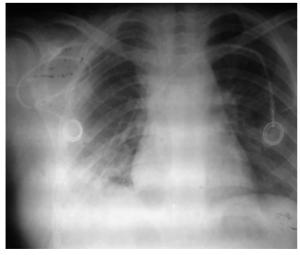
Chest X-ray with the right port tip in the right subclavian vein and the recently applied left one tip high in the SVC.
